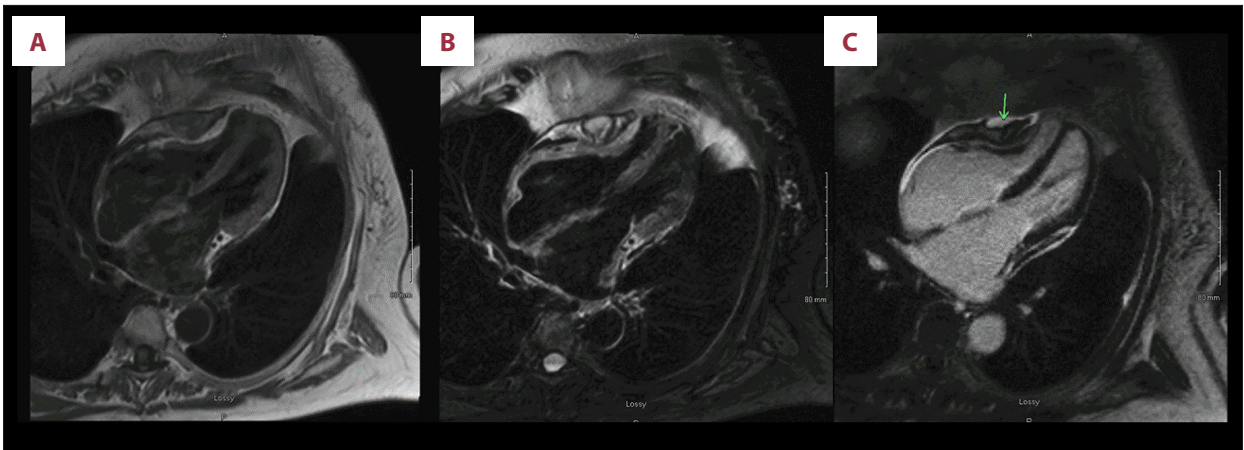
Cardiac magnetic resonance imaging. (A) T-1 weighted, demonstrates isointense soft mass measuring in the pericardial sac compressing right ventricle. (B) T-2 weighted demonstrated the mass with T2 hyper intensity. (C) Late gadolinium enhancement demonstrates intense enhancement in the pericardium and part of the soft tissue mass.
